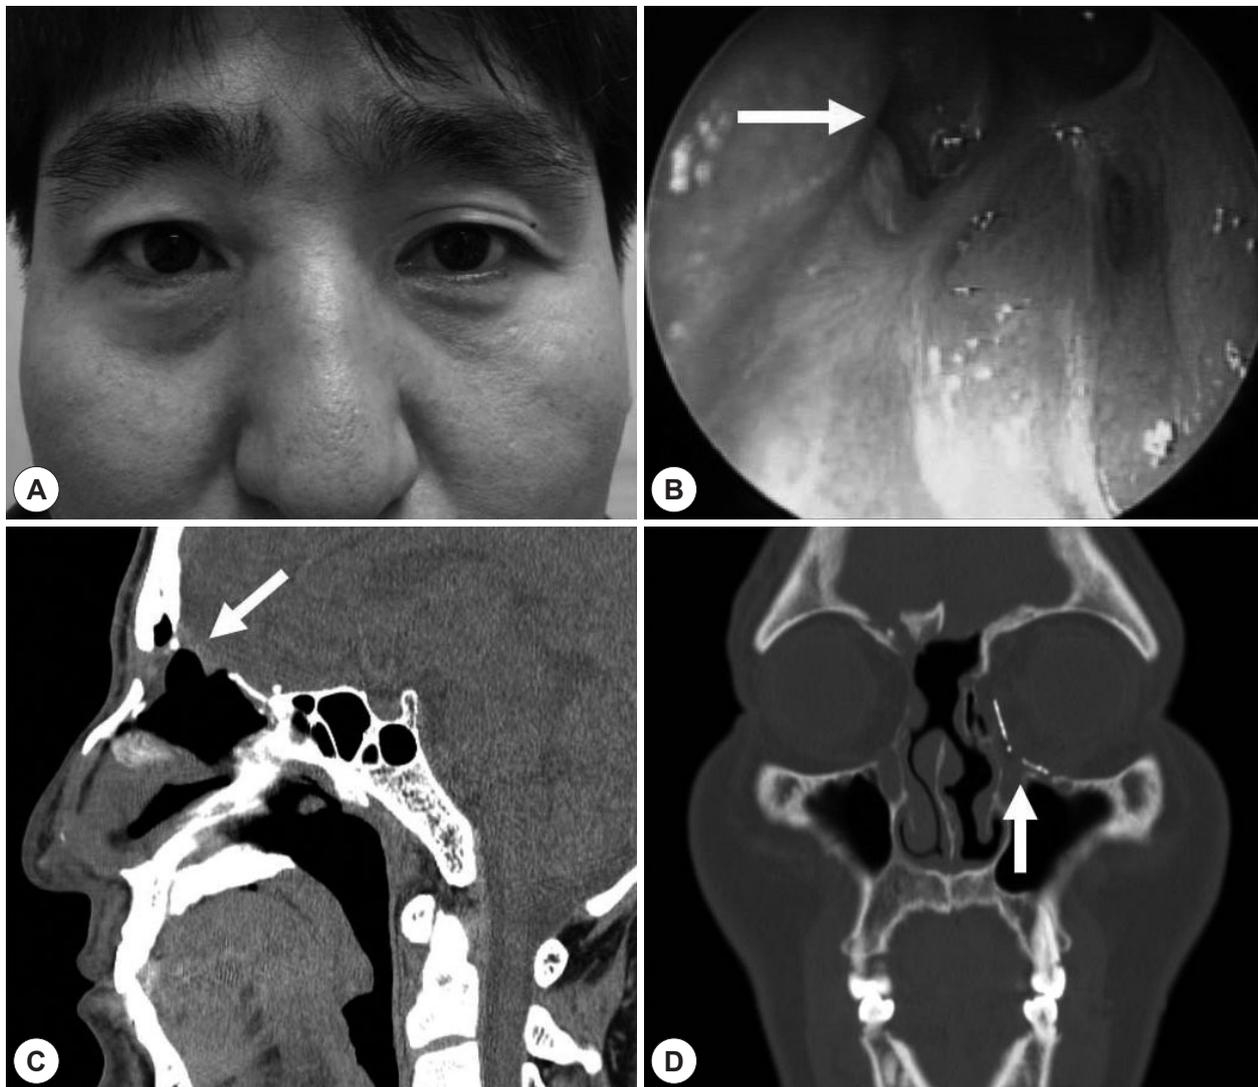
A: Postoperative 18-month facial photo showing a well healed wound without orbital displacement. B: Endoscopic exam showing repaired anterior skull base without CSF leakage (white arrow). Endoscopic follow-up of the skull base was possible at the outpatient clinic because complete ethmoidectomy was performed simultaneously at the initial surgery. C: Sagittal computed tomography scan showing a well delineated anterior skull base without herniation (white arrow). D: Coronal CT scan showing the orbit wall reconstructed with medpor implant material (white arrow).
